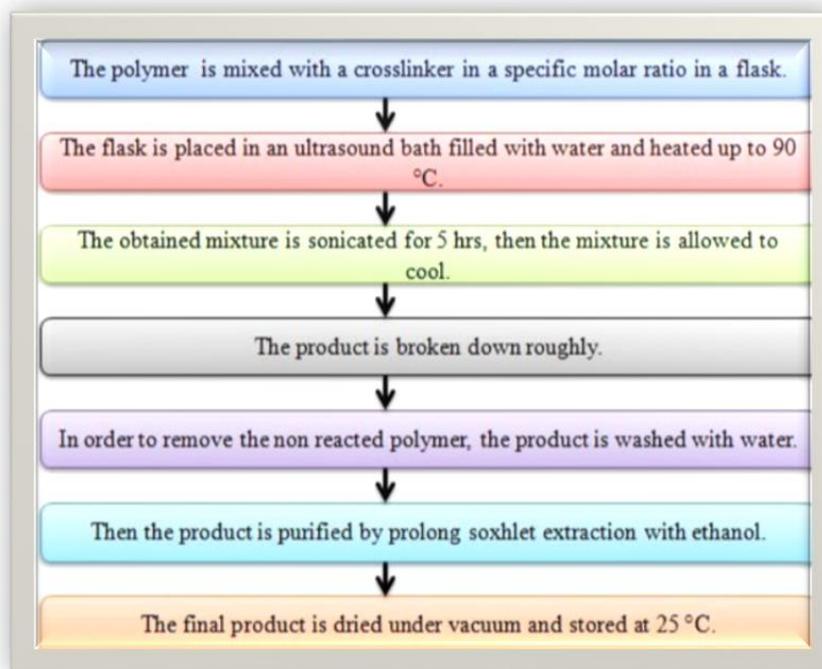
Ultrasound assisted synthesis.^[31]
